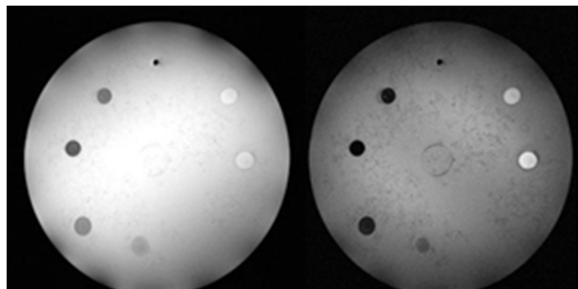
T_1 -weighted (left) and T_2 -weighted (right) MR images for $\mathbf{1}\cdot 6\text{H}_2\text{O}$
